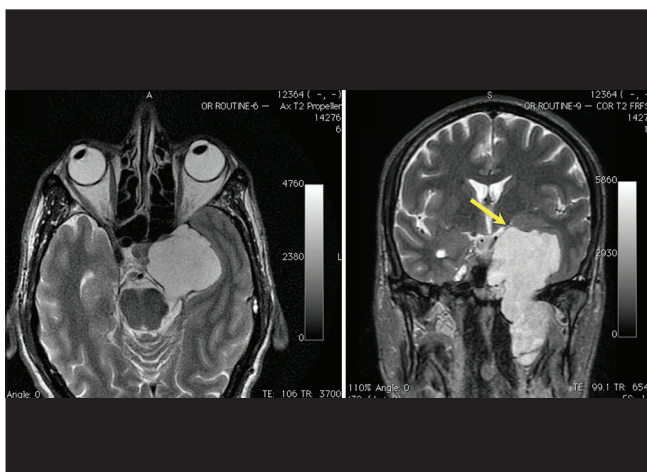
Axial T2-weighted image (Figure 1, left) and coronal T2-weighted fast relaxation fast spin-echo image (Figure 1, right) showing a large fairly well-circumscribed lobulated heterogenous mass in the left cavernous sinus, displaying a heterogenous hyperintense signal
